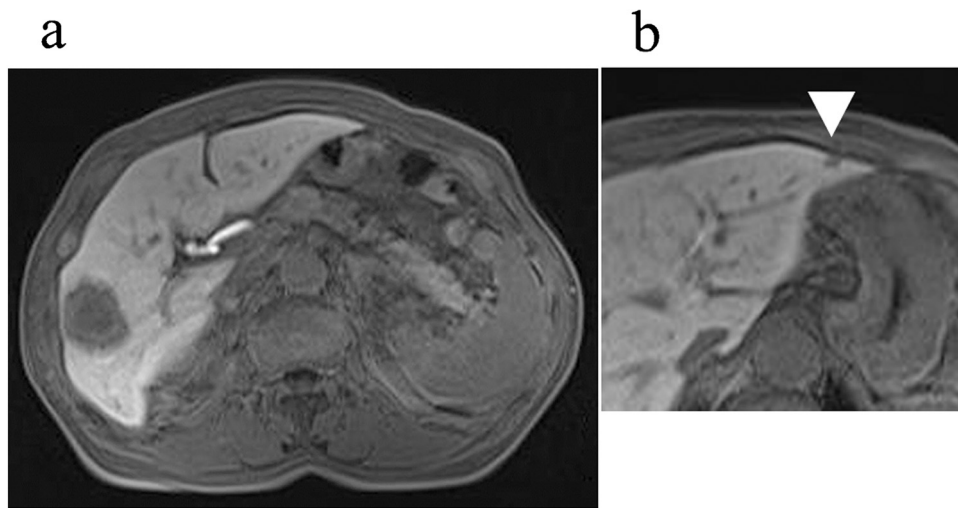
Magnetic resonance imaging (MRI) findings. Contrast-enhanced magnetic resonance imaging showed a signal-hypointense mass in segment 5/6 of the liver. A similar small nodule (arrowhead) was apparent in segment 3.
